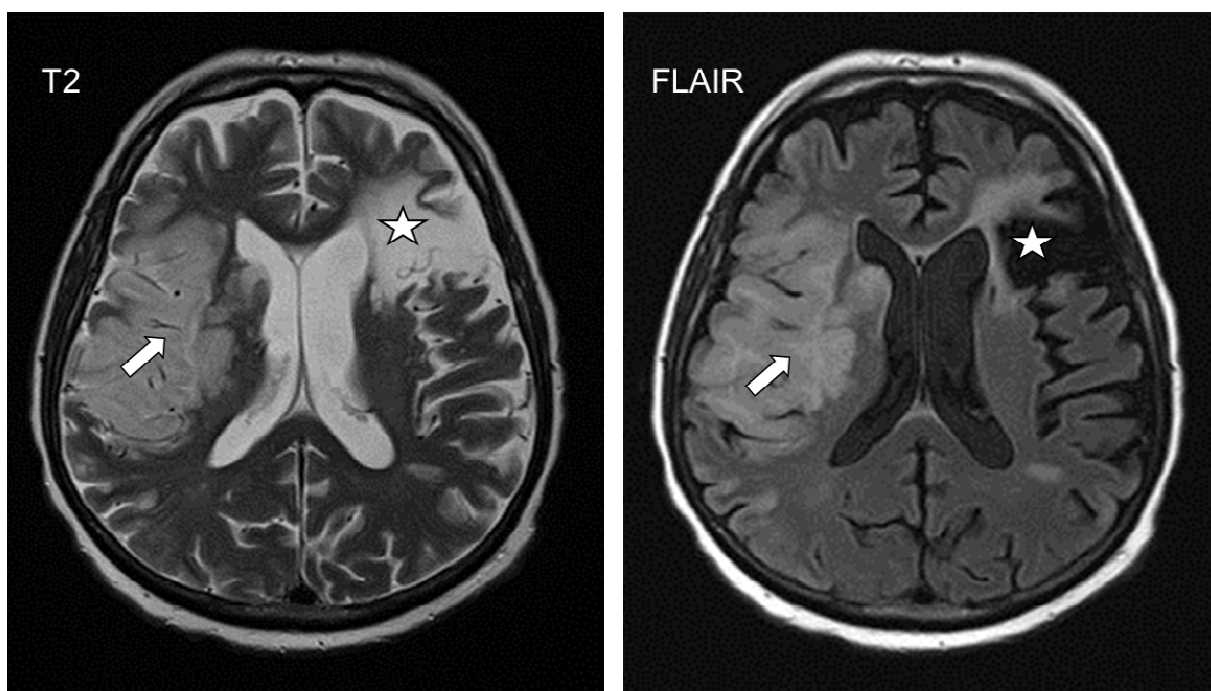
Embolic stroke after TAVI. Embolic stroke involving the right middle cerebral artery (R-MCA) distribution (arrow) after TAVI, seen on T2 and Flair MRI images. Superimposed is an old, transcortical infarct in the left frontal and parietal lobe (star). (Reproduced from *Intervent Cardiology Clinics*, Jones et al. 2015;4(1):83-93 with permission from Elsevier)[12]
